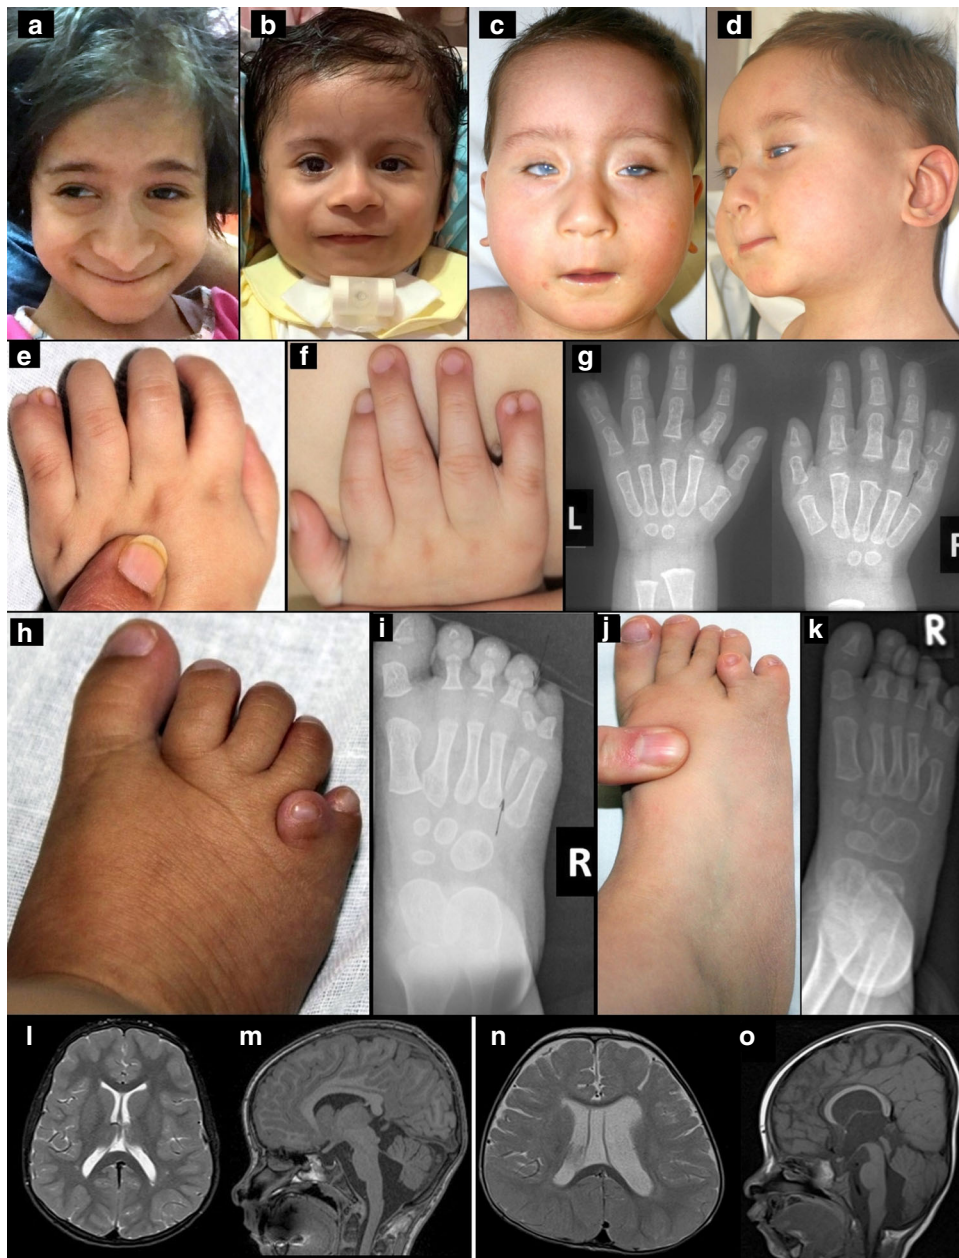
Clinical features of individuals with biallelic pathogenic variants in *MAPKAPK5*. (a) Face of affected individual 1 at 9 years showing bitemporal narrowing, long face, overhanging nasal tip, and thin lips. (b) Face of the younger sister, affected individual 2, at 2 years of age showing bitemporal narrowing, prominent forehead, sparse eyebrows, prominent nasal tip, wide nares, thin lips, and microretrognathia. (c–d) Affected individual 3 at age of 19 months with short and narrow palpebral fissures, a small mouth with thin lips, and uplifted ear lobes (c). Retrognathia and dysmorphic ears with missing crus of superior antihelix and nearly missing ear lobe can be observed in (d). (e–f) Hands of affected individual 1 showing synpolydactyly: bilateral double nail of the little fingers with partial cutaneous syndactyly between the fourth and duplicated fingers in both hands. (g) X-ray of hands of affected individual 1 showing duplication of terminal phalanx of left little finger and duplication of middle and terminal phalanges of the right little finger with short first metacarpals bilaterally. (h) Image of the right foot of affected individual 1 showing deep groove between first and second toes and a short extra digit between the fourth and fifth toes. (i) X-ray (affected individual 1) showing an extra hypoplastic metatarsal bone and an extra phalanx between the fourth and fifth toes, absent middle and terminal phalanges of the fifth toe and hypoplastic middle and terminal phalanges of the second, third, and fourth toes in right foot. (j) Affected individual 3: synpolydactyly with an additional hypoplastic toe between the fourth and fifth toes of the right foot. (k) X-ray of the right foot of affected individual 3 showing synpolydactyly with an extra hypoplastic metatarsal bone between the fourth and fifth metatarsals and an extra proximal phalangeal bone between the fourth and fifth toes. (l–m) Magnetic resonance image (MRI) brain of affected individual 1 at 9 years. L: T2 axial cut showing mild demyelination around the occipital horn of the lateral ventricles. M: sagittal cut showing thin body of corpus callosum, prominent cerebellar folia, and vermian hypoplasia. The fourth ventricle is communicating with extra axial cerebrospinal fluid (CSF). (n,o) MRI brain of affected individual 2 at 18 months. (n) T2 axial cut showing cavum septum pellucidum, asymmetric dilatation of lateral ventricles with more dilatation on the left side. (o) Sagittal cut showing thin arched corpus callosum, prominent cerebellar folia, and mild vermian hypoplasia. The fourth ventricle is communicating with extra axial CSF.
